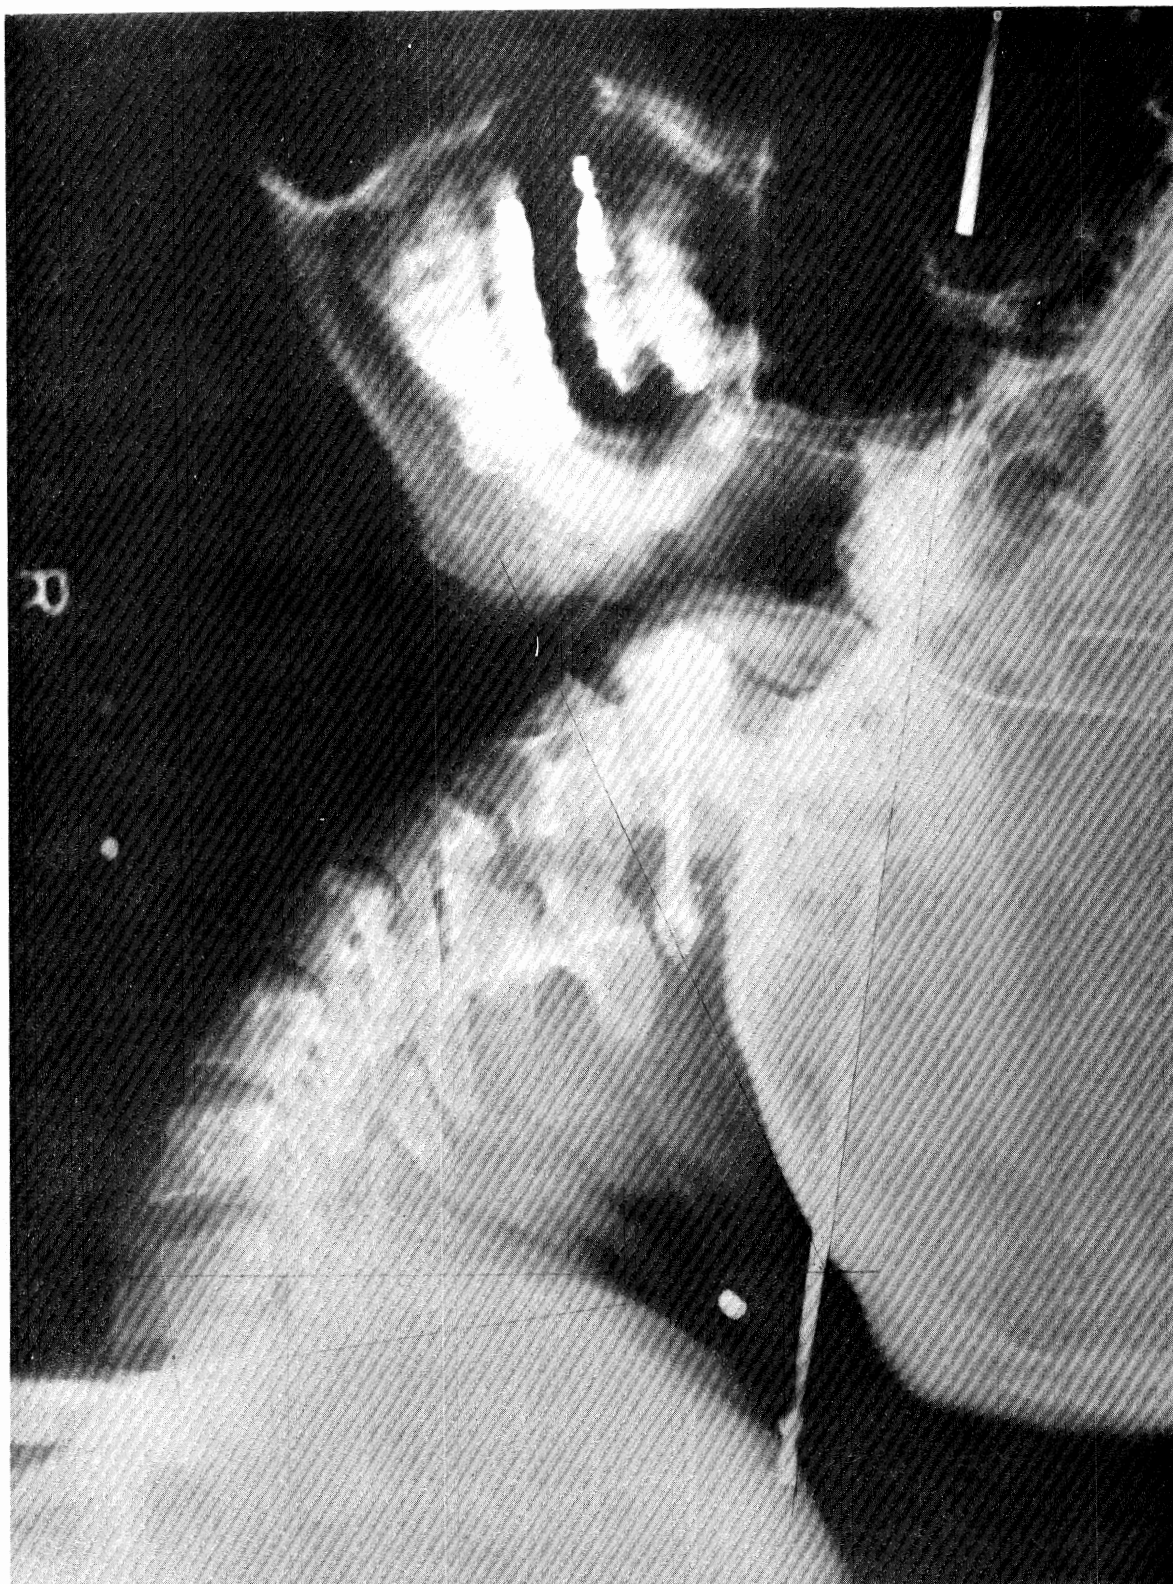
Lateral X-ray of Subject in Extension. Note Position of Rod and Amount of Skin Compression as Indicated by C-5 and C7 Markers. It is this Skin Excursion Which is Thought to Cause the Headpiece, and Hence the Rod, to Shift Occasionally in Relation to the Skull.
